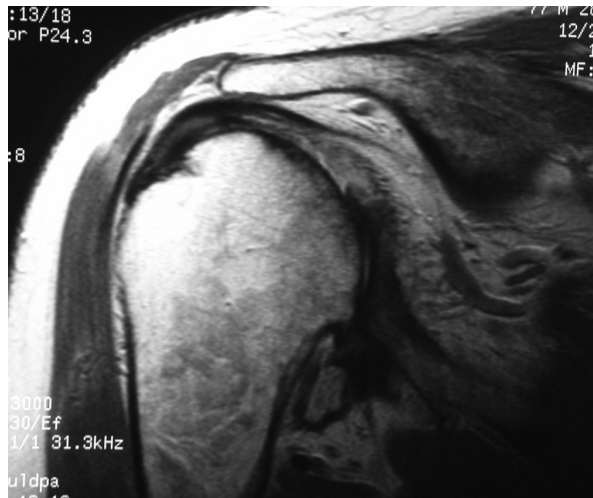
MRI demonstrating humeral head migration superiorly with rotator cuff arthropathy.
